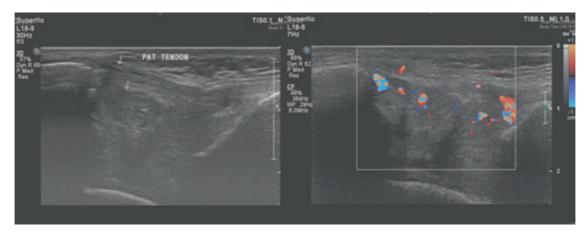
Focused USG Doppler screening showed hypoechoic spaces demonstrating venous pattern vascularity.
